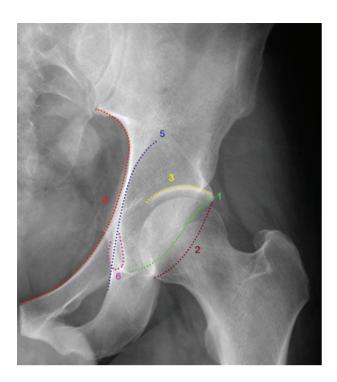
Pelvic X-ray assessment The six lines of the acetabulum: 1 anterior wall of the acetabulum; 2 posterior wall of the acetabulum; 3 roof or dome of the acetabulum; 4 iliopectineal line – this corresponds to the anterior column of the acetabulum; 5 ilioischial line – this corresponds to the posterior column of the acetabulum; and 6 teardrop.
